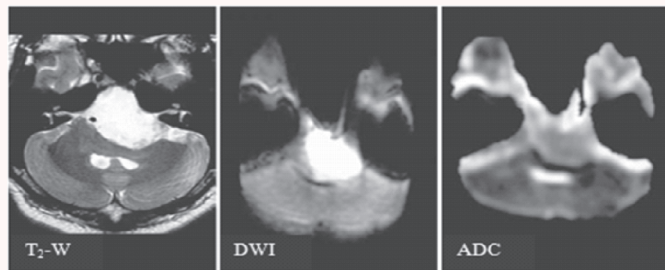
An expansive lesion in the left aspect of the posterior fossa, demonstrating similar signal intensity to CSF and high signal intensity on diffusion-weighted imaging (DWI). (Diagnosis: Epidermoid)
